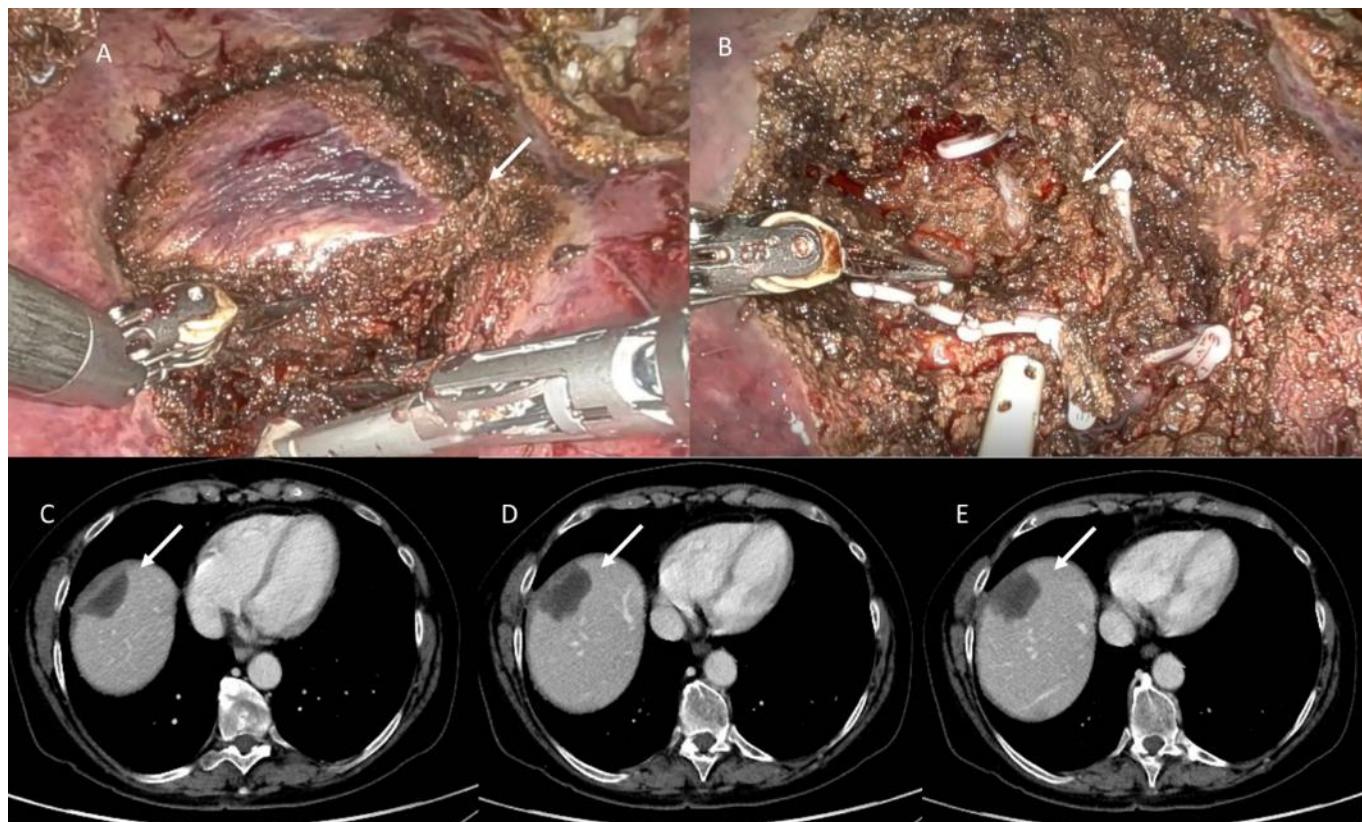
In (A,B) robotic atypical resection of lesion located in segment VIII. In (C–E), CT evaluation: arrows show fluid collection.
